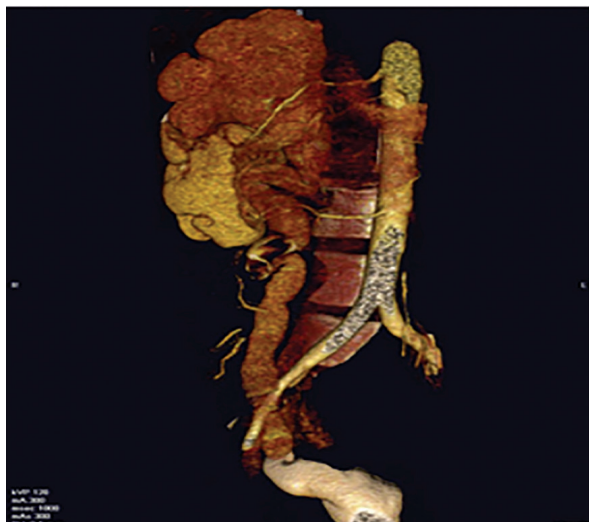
Three dimensional reconfiguration of computed tomography demonstrating the non-functioning upper pole moiety.
